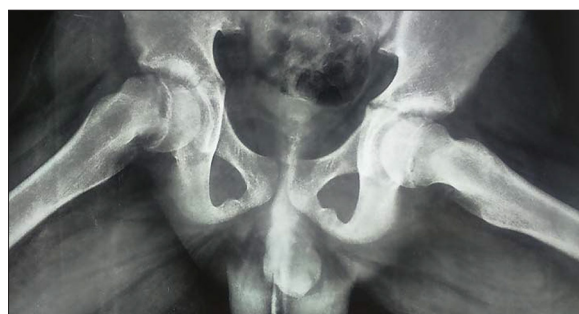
Plain radiograph taken in frog leg position showing a widening of the right proximal physis below the right femoral head with a medial and posterior slip of the right femoral head.
